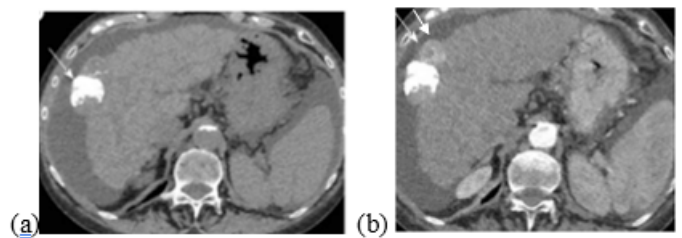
Lesional aspects of CHCs on CT before lipiodol-assisted CHE.
